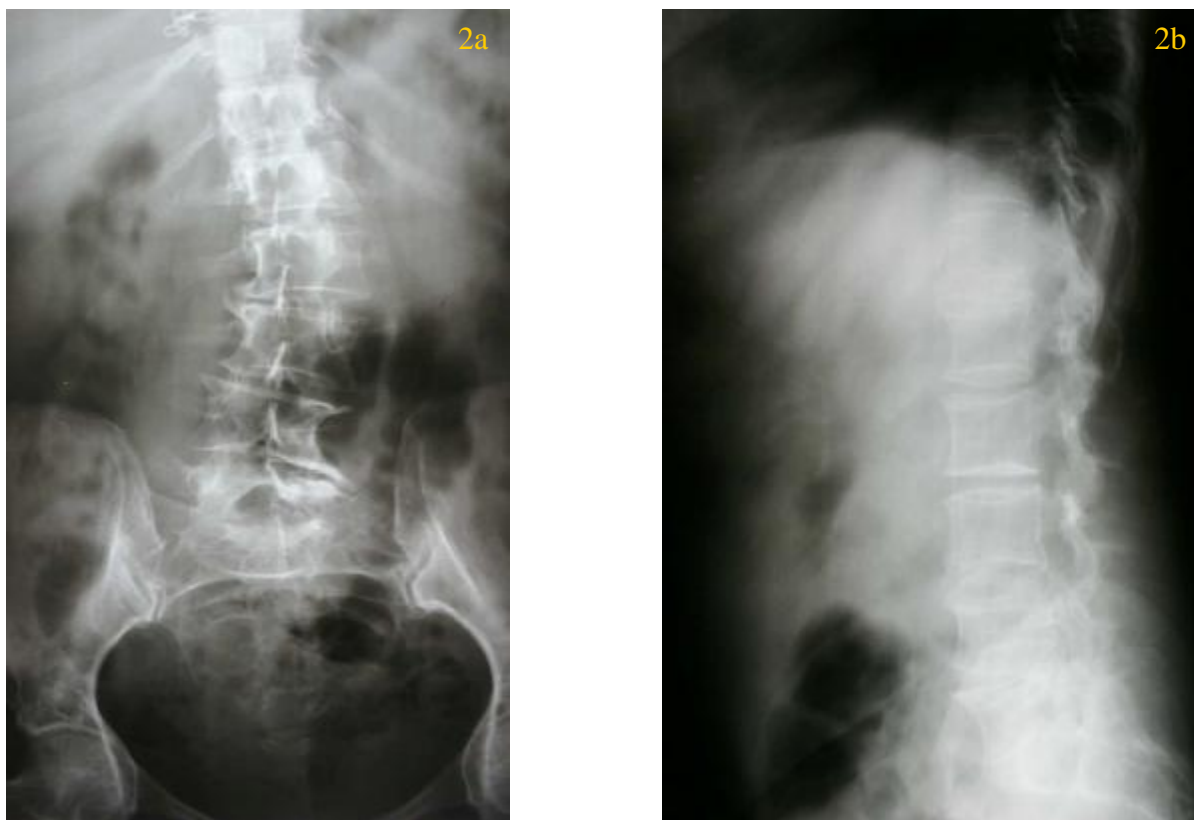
Anteroposterior and lateral lumbar X-rays showing flattening of the normal curve of lumbar vertebra and scoliosis with right-sided curve, narrowing in L2-3 on the right-side and in L5-S1 on the left-side, sclerosis and degenerative osteophytes.
